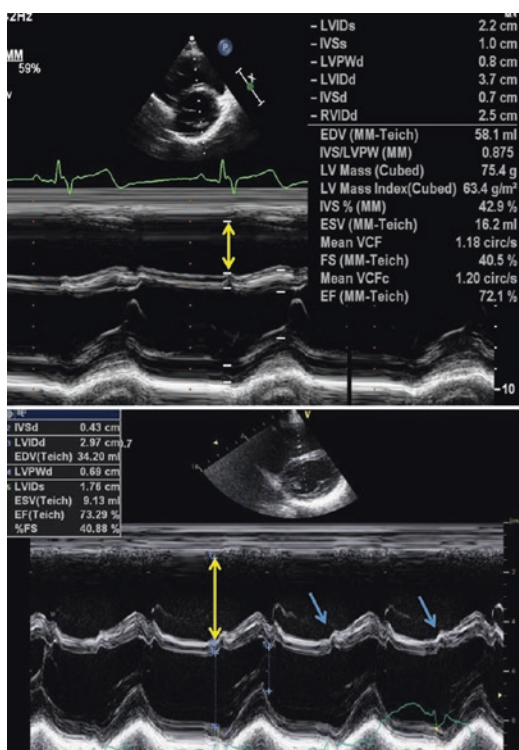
Measurement of RV dimension from the parasternal short axis M-mode in patients after TOF repair. In the *upper panel*, the RV is positioned nicely anterior to the LV and the M-mode is a *straight line* through the RV trabecular part just below the RVOT. In the *lower panel* it is difficult to obtain an image with the RV positioned anterior to the LV. There is abnormal septal motion related to early septal activation and delayed anterior wall activation resulting in the inward septal motion during the R-wave (*small blue arrows*)
